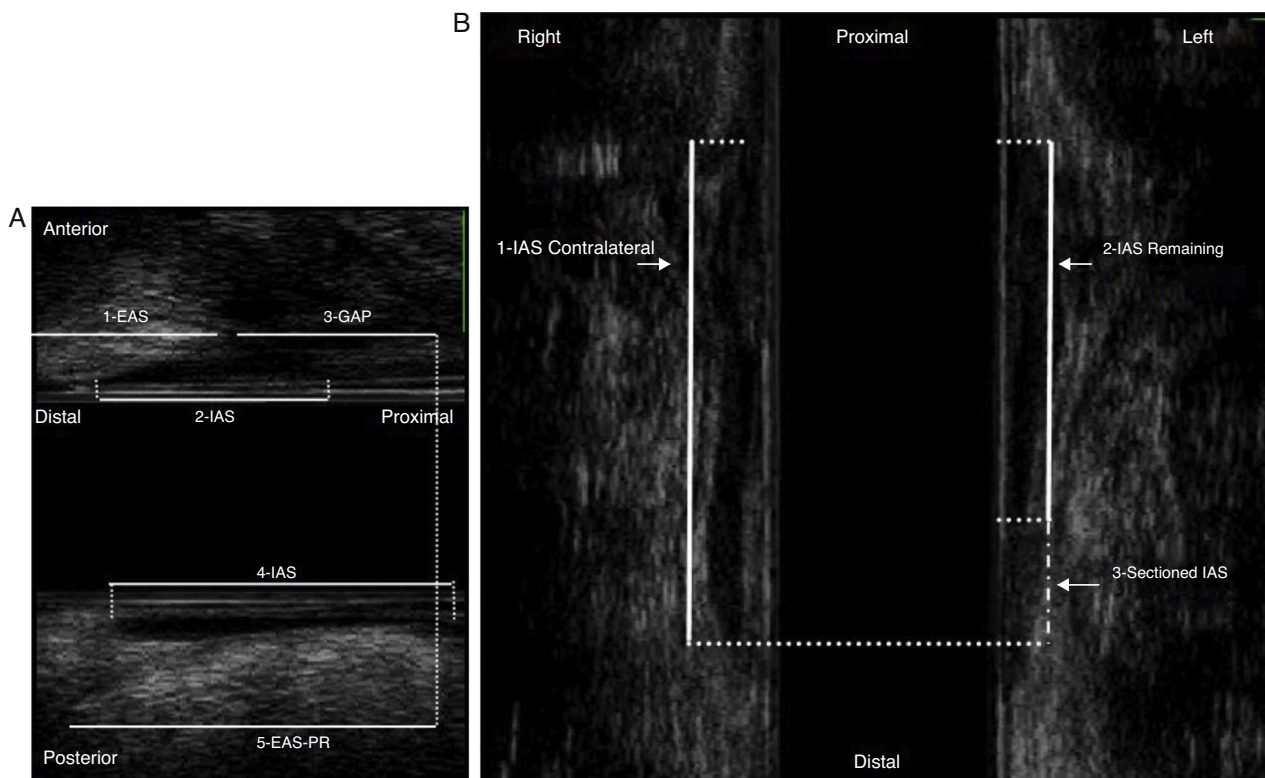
(A) Anal canal of female patient (sagittal plane). Sonographic parameters: 1, length of previous EAS; 2, length of previous IAS; 3, length of the gap; 4, length of posterior IAS; 5, length of EAS-PR complex. (B) Anal canal of female patient (coronal plane) – sonographic parameters: 1, length of contralateral IAS; 2, length of remaining IAS; 3, length of transected IAS (dashed line).
